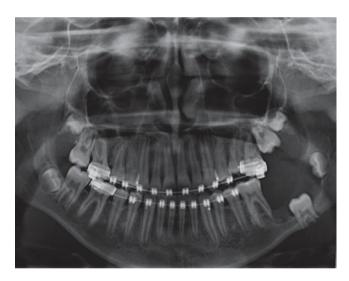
Panoramic radiograph demontrates large, unilocular, radiolucent lesion in the left mandible associated with the crown of the impacted second mandibular molar, which is inferiorly displaced. The lesion extends from the first molar to mid ramus, with displacement of the third molar bud
